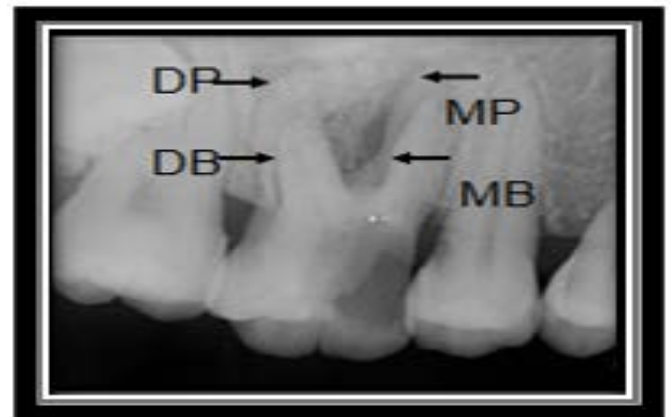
preoperative radiograph of 26.
